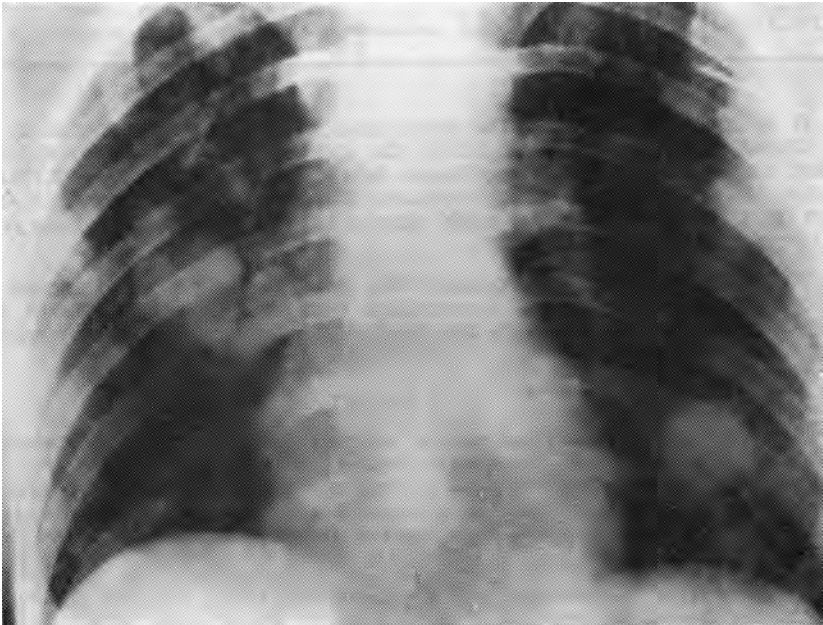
Roentgenogram of the chest showing two coin lesions.
